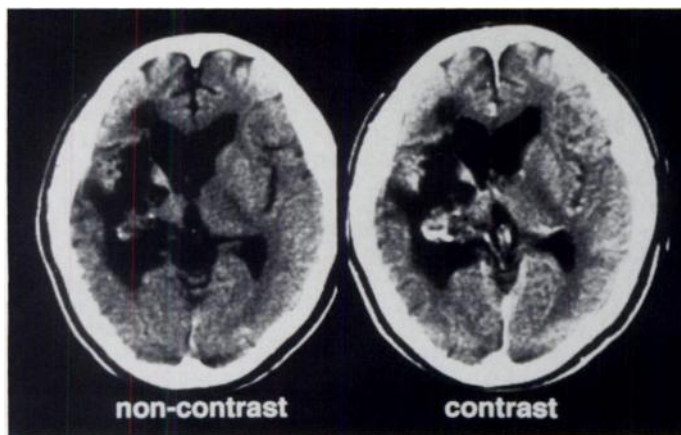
Noncontrast and contrast-enhanced CT images in 1995, 2.5 yr after the last episode of bleeding, still showed the regressed AVM.
